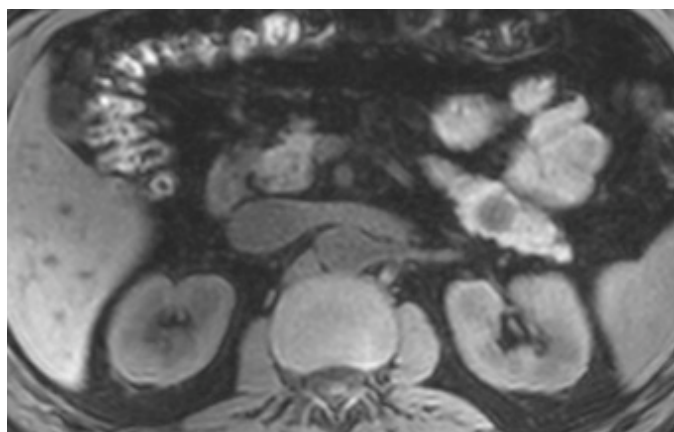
Poorly differentiated pancreatic NET in the head. A. Transverse T2-weighted MRI showing the pNET slightly hyperintense (arrow). B The pNET is markedly hypointense in the T1-weighted MRI. C. Transverse T1weighted gadolinium contrast-enhanced MRI in the arterial phase. D. Transverse diffusion-weighted MRI (DW MRI) b 800 showing the high signal of the pNET (arrows). E. DW MRI, attenuation diffusion cartography (ADC), showing a very low signal, measured at a value of 1, the lesion was grade 3, poorly differentiated.
